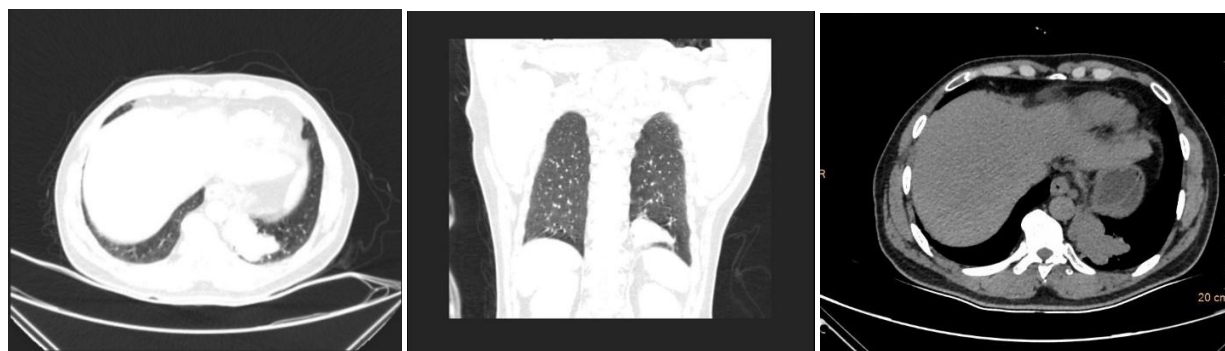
HRCT chest axial and coronal sections in lung and mediastinal window showing triangular mass of non-aerated lung occupying postero-basal segment of left lower lobe.
